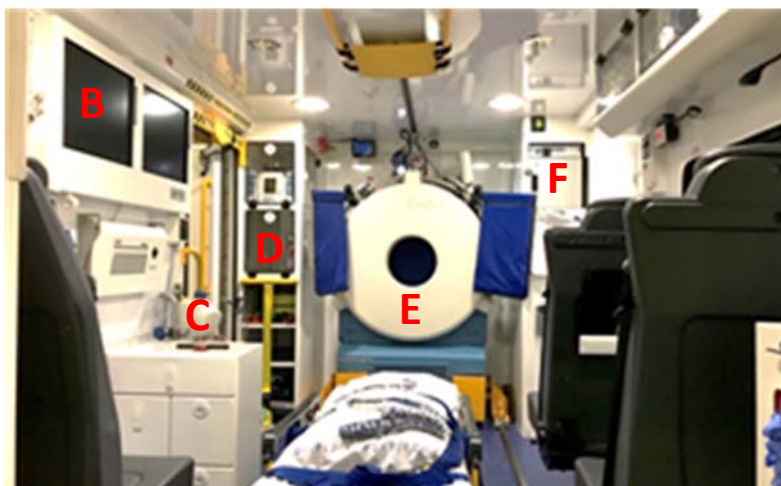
Melbourne Mobile Stroke Unit exterior (A) and interior hardware comprising monitors for viewing and sending imaging in real-time (B), contrast injector (C), storage compartments for medications (D), CereTom[®] CT scanner (E) and contrast warmer (F).
